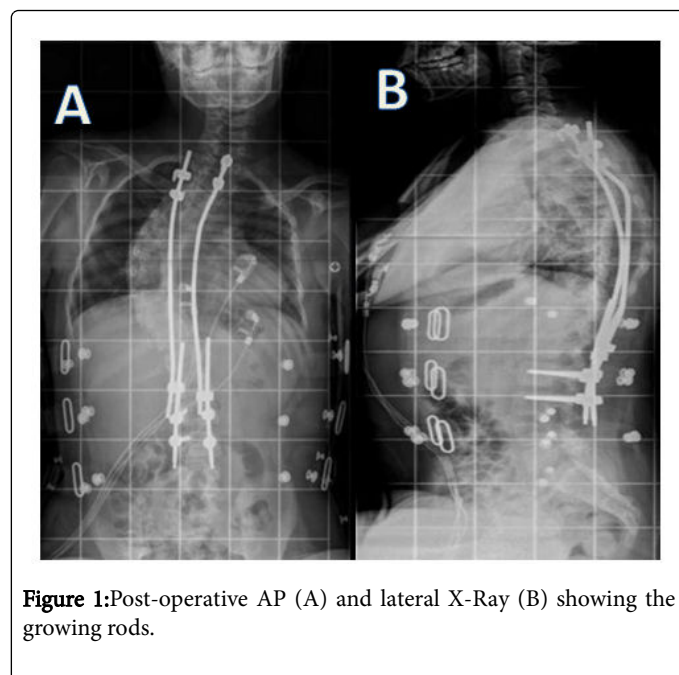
Post-operative AP (A) and lateral X-Ray (B) showing the growing rods.
